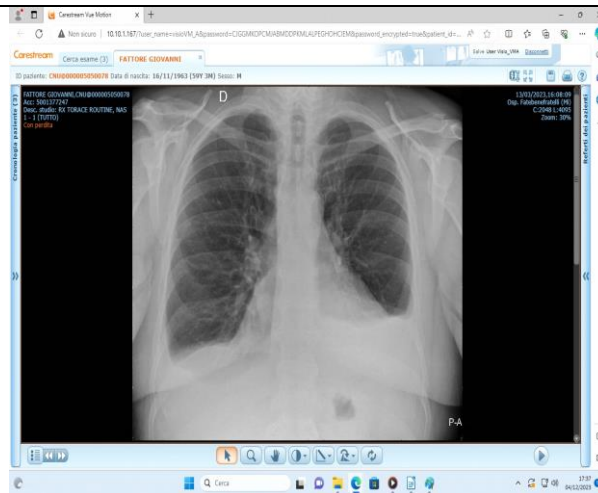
Second chest x-ray which highlights a slight enlargement of the cardiac area compared to the previous check-up and the unchanged presence of the pleural effusion.
